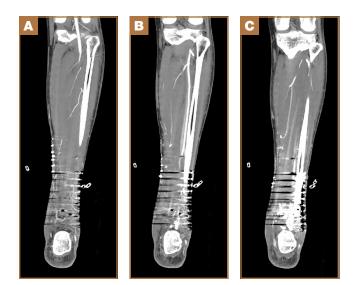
Computed tomography (CT) angiogram shows 1 vessel run off of peroneal artery in distal leg. (A–C) Sequential coronal CT angiogram sequences.
